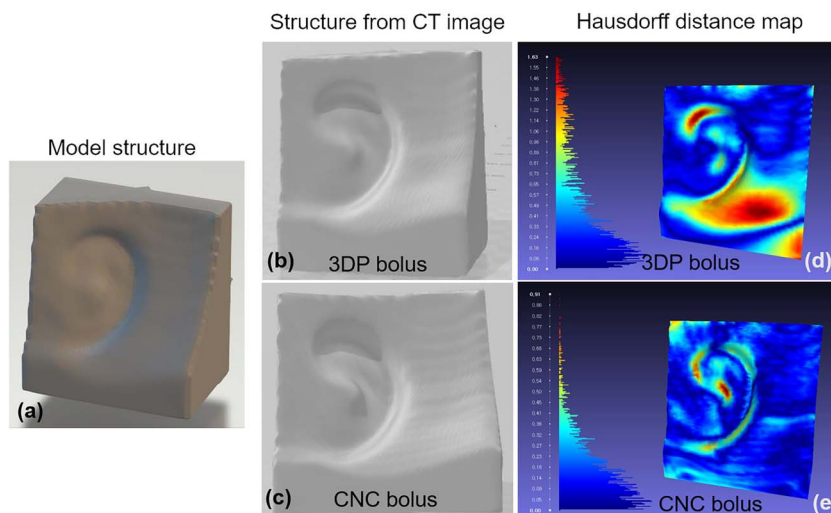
Screenshot of Meshlab (Visual Computing Lab, ISTI-CNR, Pisa, Italy) comparing the (a) original ear bolus structure to the CT-scanned ear bolus manufactured by (b) 3DP mold and (c) CNC mode, depicting the Hausdorff distance in RGB color scheme for (d) 3DP and (e) CNC bolus.
